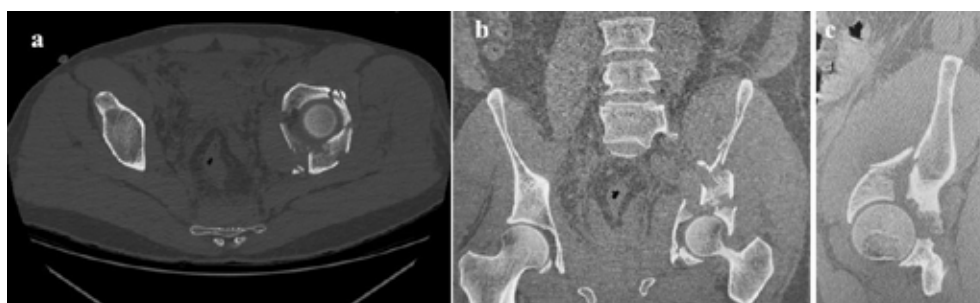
Case 2 CT scan. a) axial view-quad is detached, b) coronal view-transtectal transverse fracture. iliac wing is also fractured, c) sagittal view
